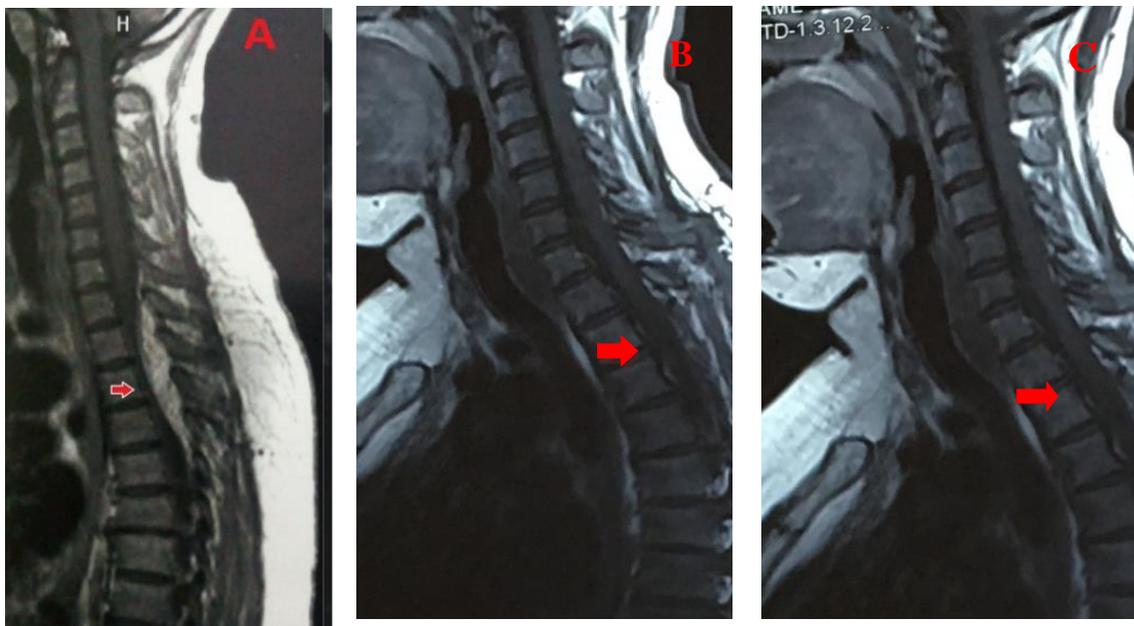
Spinal MRI. A: sagittal injected sequence; B, C: MRI control sagittal injected sequence; showing a total tumor removal .
